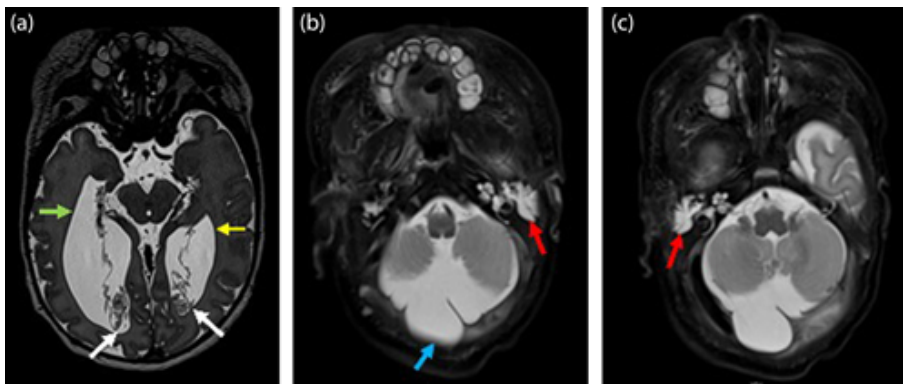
(a) MRI brain (DRIVE images) showing bilaterally dilated lateral ventricles with frontal horn width on right (green arrow; 6 mm) and left (yellow arrow; 6.7 mm). Occipital horns are dilated out of proportion to frontal horns suggestive of colpocephaly. Dangling choroid plexus (white arrows) can be seen in the lateral ventricles. (b) Prominent retrocerebellar CSF space with septations within suggestive of a prominent cisterna magna or arachnoid cyst (blue arrow) was seen on the T2W sequence with no mass effect on the cerebellar parenchyma. (c) Fluid signal intensity was seen in the middle ear and mastoid antrum bilaterally in T2W sequence (red arrows in (b) [left ear] and (c) [right ear]).
